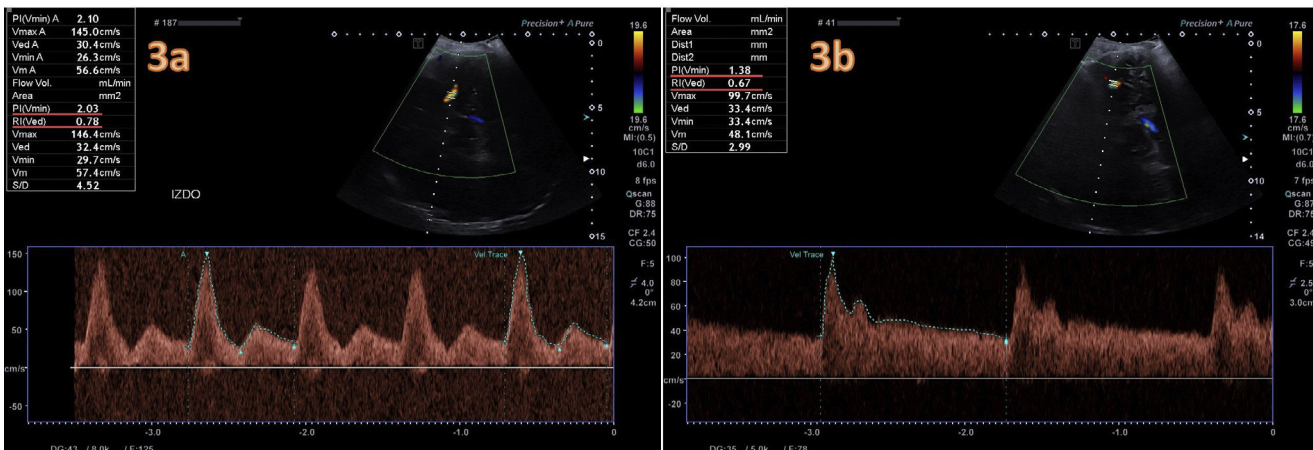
(a) Transcranial Doppler ultrasound of the flow of the left middle cerebral artery through the transtemporal window at diagnosis. Abnormal waveform at baseline, with a pulsatility index (PI) of 2.1 and a resistive index (RI) of 0.78, suggestive of IICP. (b) Measurement at 5 days of treatment with changes in the waveform and a decrease in both indices (PI, 1.38; RI, 0.67).
